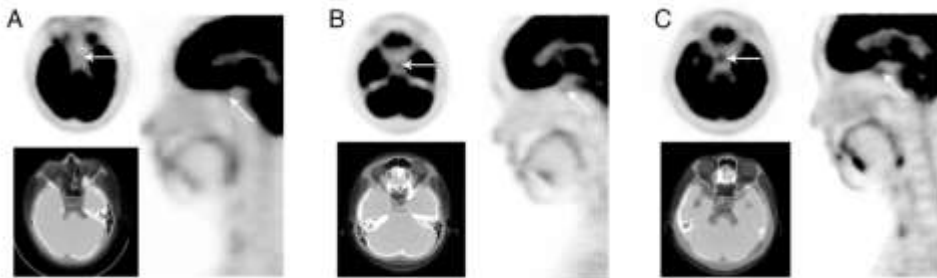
FDG PET images showing various levels of FDG uptake in the pituitary fossa in subjects with different serum TSH levels. (A) Scanty pituitary FDG uptake in a subject with low TSH (0.11 μ IU/mL); (B) moderate pituitary FDG uptake in a subject with normal TSH (3.27 μ IU/mL); and (C) intense pituitary FDG uptake in a subject with high TSH (9.28 μ IU/mL).
